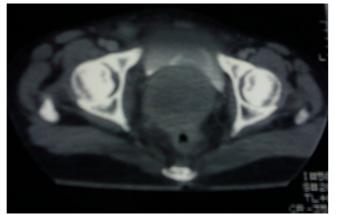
Abdominal CT scan showing large mass in cervix.
